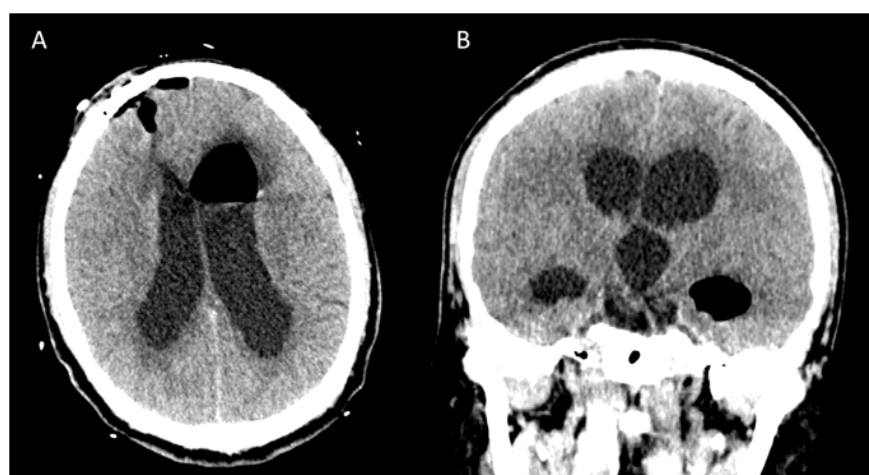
Head CT transaxial (A) and coronal (B) images showed ventricular air quota in the left frontal horn and in right temporal lobe due to previous biopsy and dilation of the supratentorial ventricular system particularly evident at the level of the third ventricle indicative of hydrocephalus.
